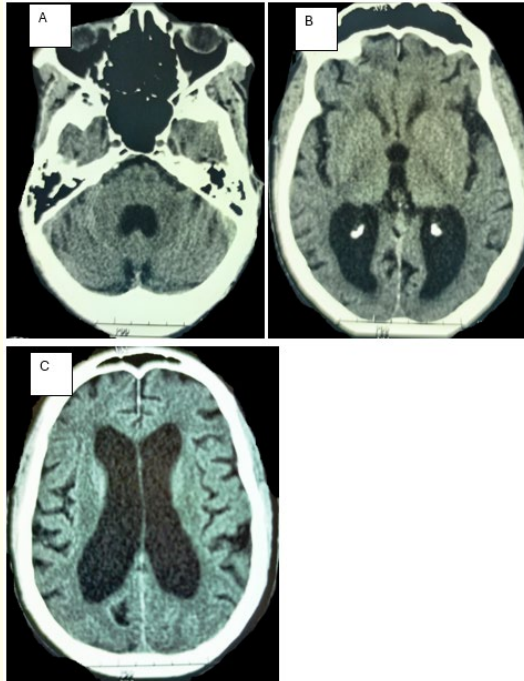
Cranioencephalic CT scan of a patient admitted with Adams and Hakim triad. These axial sections show tetra-ventricular hydrocephalus with dilatation of the fourth ventricle (A), dilatation of the third ventricle (B), dilatation of the lateral ventricles (C), cortical atrophy and periventricular hypodensity of transependymal resorption.
